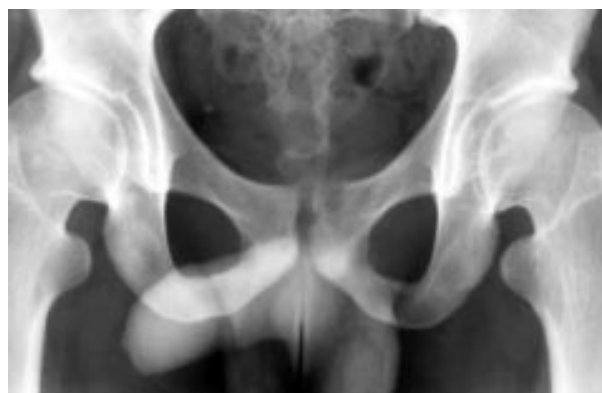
Radiograph of the os pubis showing an unclear lining of the symphysis pubis and bony destruction. Normal anatomy, no diastasis.
